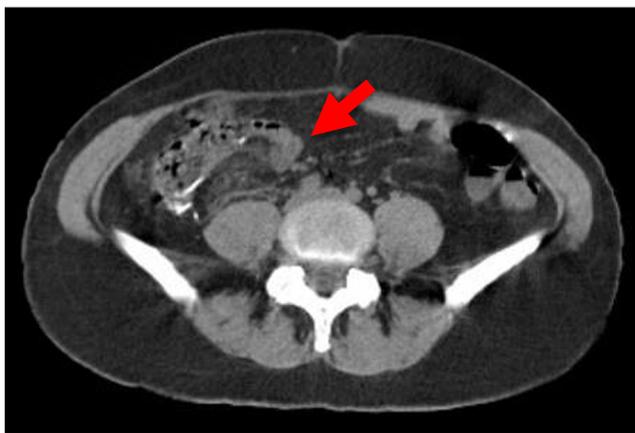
CT image showing the recurrence of signet-ring cell carcinoma at the ileocolic anastomosis (red arrow)
